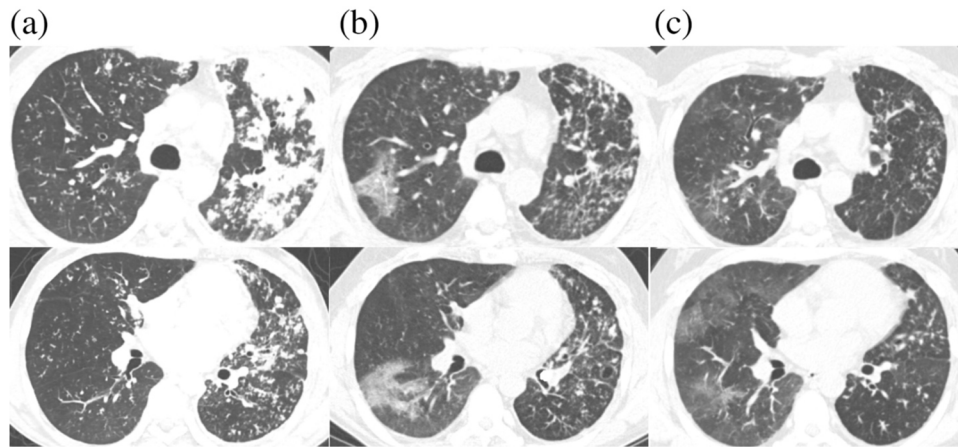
CT chest from left to right: upper lobes (top) and lower lobes (bottom) shown at (a) beginning of treatment for *Mycobacterium tuberculosis*, (b) onset of dry cough and fever, (c) eight weeks after cessation of INH and initiation of systemic glucocorticoid therapy.
